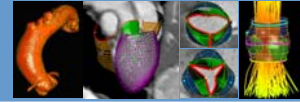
Aorta model derived from 3D MRI data (left) and initial visualization of the blood flow using line glyphs scaled according to the velocity magnitudes (right).
